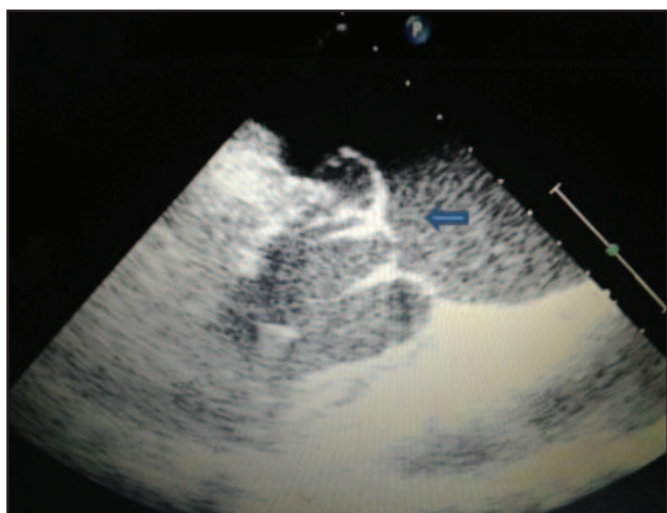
The trans-thoracic echocardiography in short-axis view showed a mitral valve prolapsed with thickened and billowing leaflet above the plane of annulus (transverse arrow). The chords are elongated.
